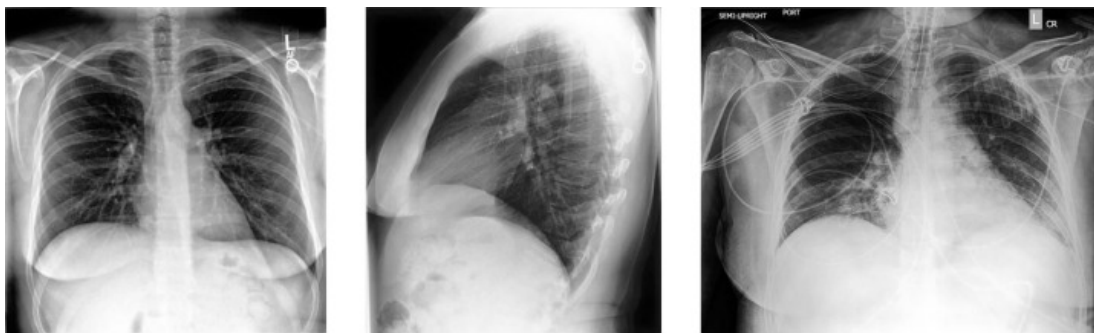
Left: posterior-anterior (PA) frontal chest radiograph. Middle: lateral chest radiograph. Right: Anterior-posterior (AP) view chest radiograph [13]
